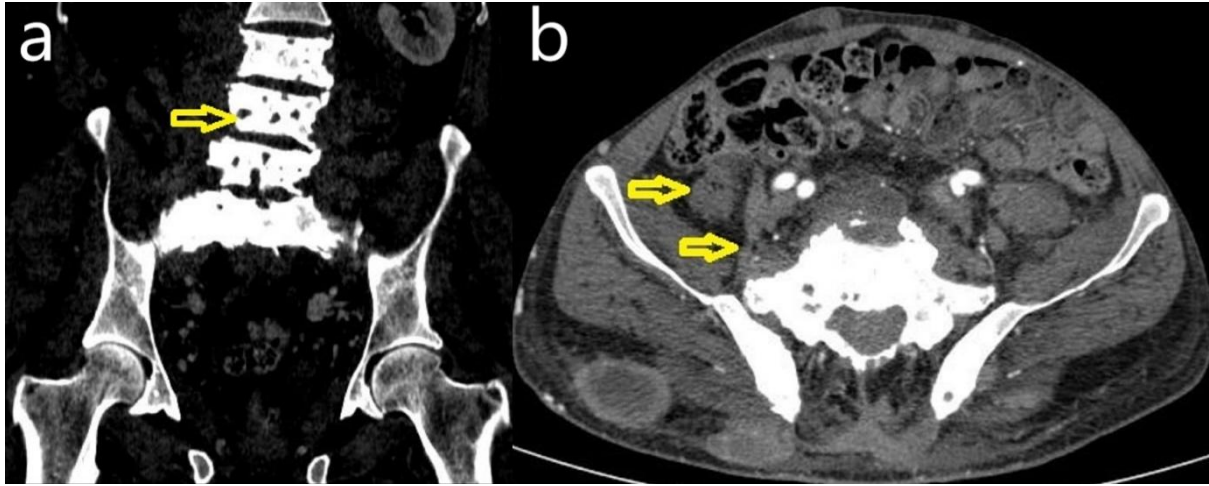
a) Coronal CT scan showing bony erosions with destructive lytic lesions (yellow arrow). b) Axial CT scan showing multiple fluid filled abscesses (yellow arrow)
